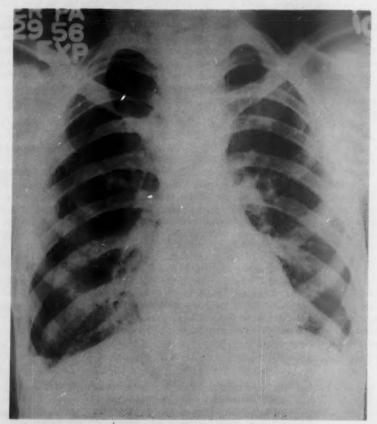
Roentgenogram on nineteenth hospital day, showing right-sided pneumothorax with prominent subpleural radiolucency.
